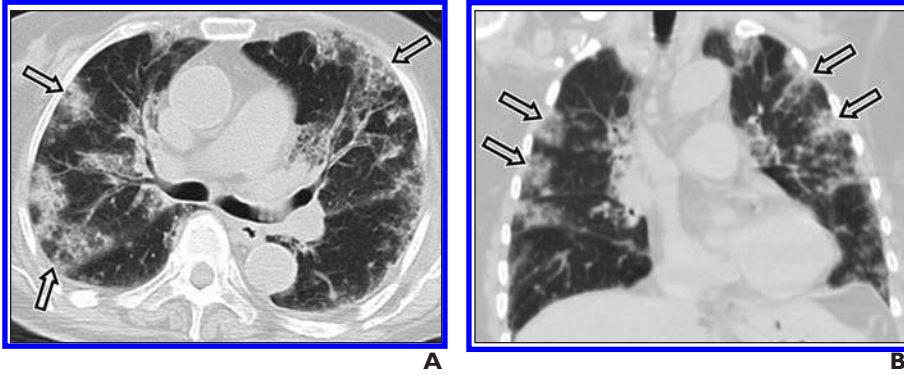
Chronic eosinophilic pneumonia. A and B, Transverse (A) and coronal (B) CT images of chest show consolidations (*arrows*) that predominately show peripheral bandlike appearance in upper lobes.
